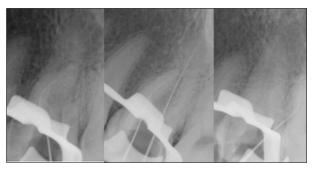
Radiographic conductometrics. Path of dilacerated ducts.
